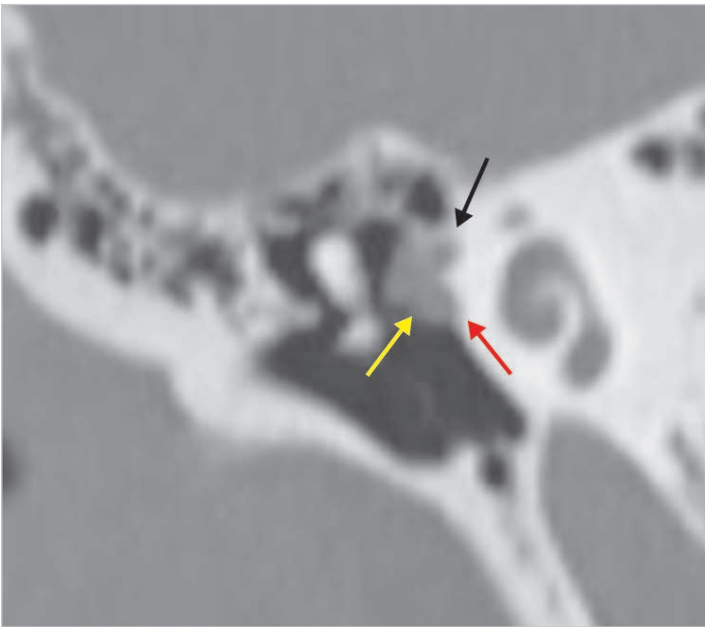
CT scan of the same case, coronal view. The cholesteatoma mass extends to the anterior epitympanic area medial to the malleus (yellow arrow) covering the tympanic segment of the facial nerve (black arrow) and the tensor tympani muscle (red arrow).
